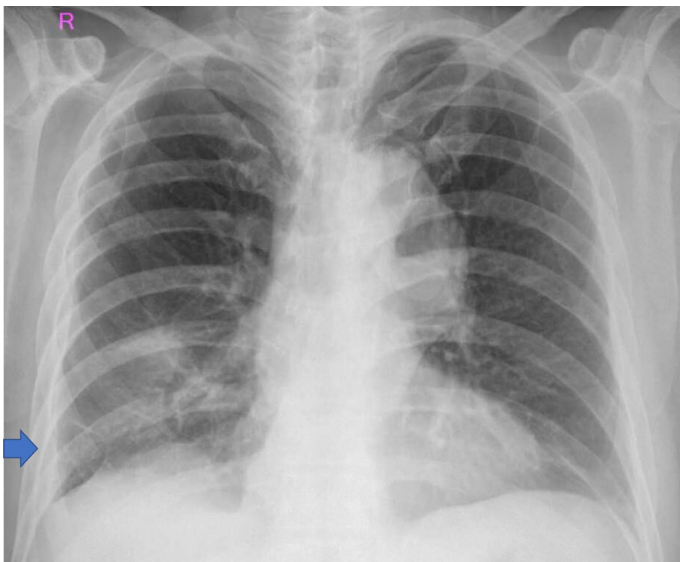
Chest X-ray taken on the fourth day post-operation.
